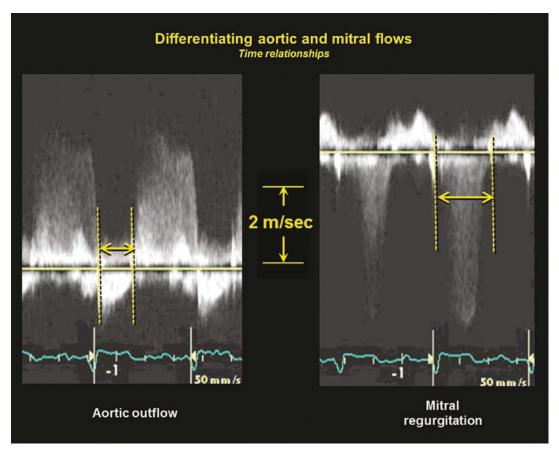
Continuous wave Doppler recordings through the aortic outlflow (left panel) and mitral inflow (right panel) to differentiate systolic aortic flow from mitral
